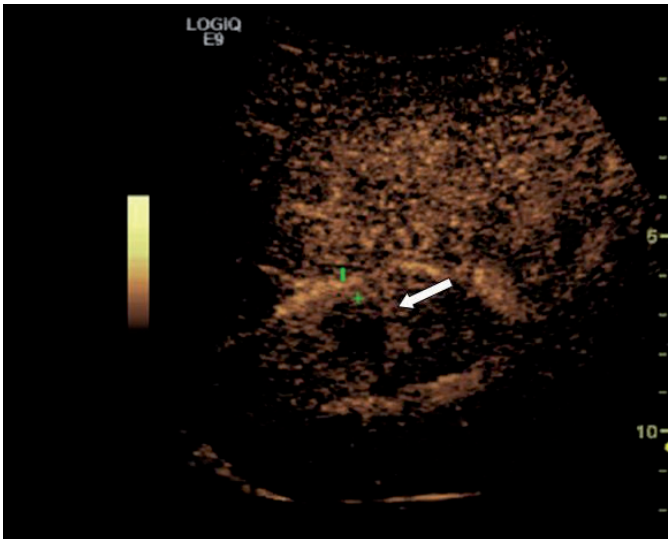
Using an ultrasound contrast agent, the segment VII lesion (arrow) which is hypoechoic during the late phase, provides the best indication of malignancy. It is also very clearly distinguishable from the adjacent hepatic parenchyma.
